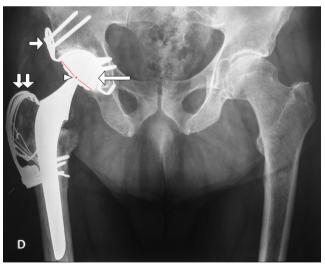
Standard non-weight-bearing anteroposterior pelvic radiograph taken 6 weeks after the last revision hip surgery for instability in a 67-year-old man showing the properly positioned acetabular reinforcement metallic device (*small arrow*), cemented acetabular shell of a dual mobility cup (*long arrow*), and a trochanteric hook (*double arrows*) to prevent greater trochanteric non-union after repeated transtrochanteric approaches. Note the position of the femoral head-neck centered in the acetabular shell (*arrowhead*)
